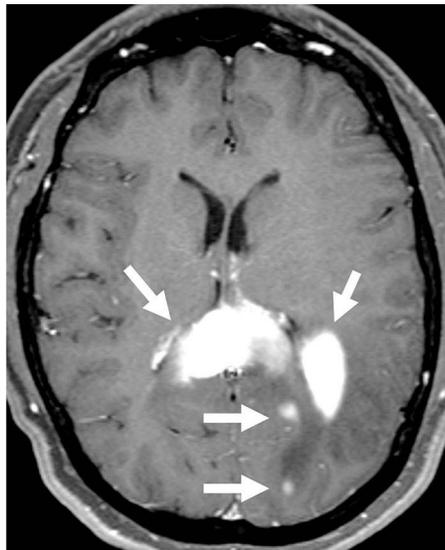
MRI Imaging at Second Relapse. Contrast enhanced axial MRI showing infiltrative, multifocal, enhancing mass lesions with one of the larger components centered within the splenium of the corpus callosum.
